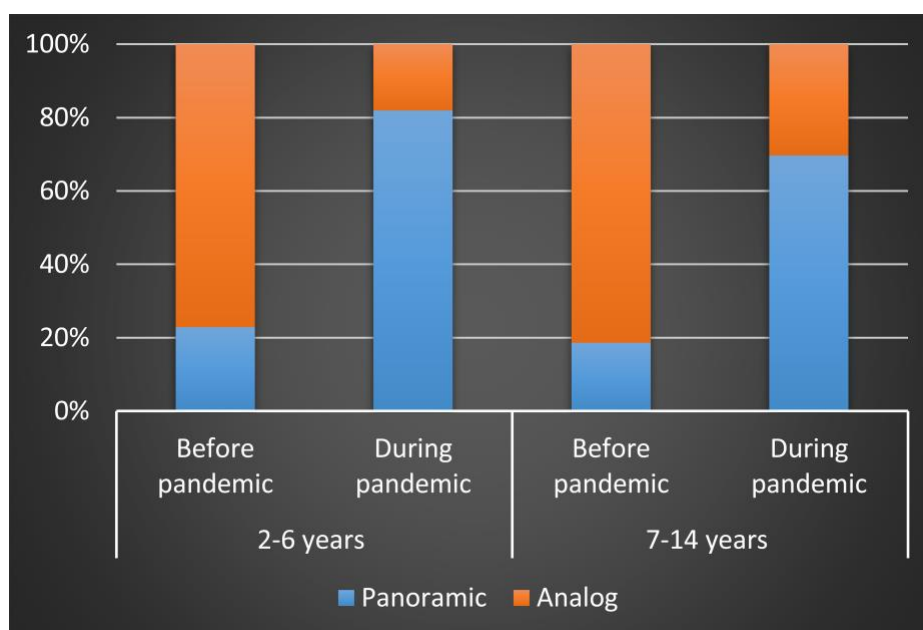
The rates of panoramic radiograph by age and period in total radiograph
